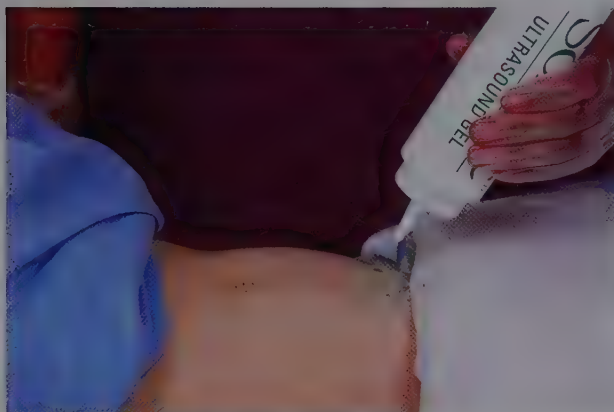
Echocardiographer. A. Normal echocardiogram sonographic image. B. The sonographer places the transducer in a left intercostal space in the parasternal line, overlying the heart to obtain image A. (Reprinted with permission from Moore KL, et al. *Clinically Oriented Anatomy*. 7th ed. Philadelphia, PA: Wolters Kluwer Health; 2013.)
